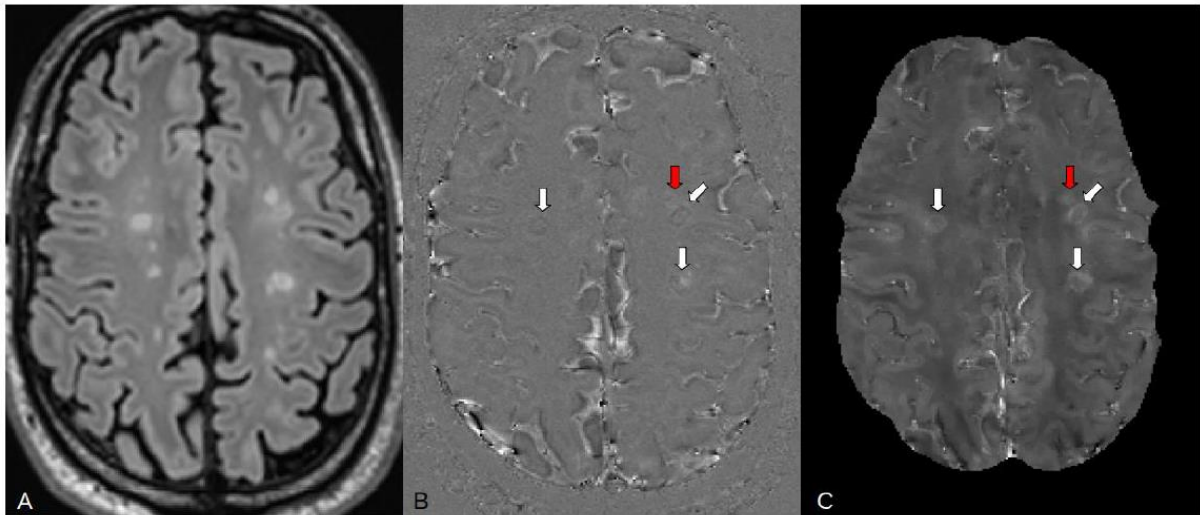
Example of hyperintense lesions on FLAIR (A) presenting as paramagnetic rim lesions on unwrapped filtered phase (B) and quantitative susceptibility mapping (C). White arrows indicate paramagnetic rim lesions; the lesion indicated by the red arrow shows a paramagnetic rim that is only partially visible in this slice. From Cagol et al., *Neurology*, 2023
